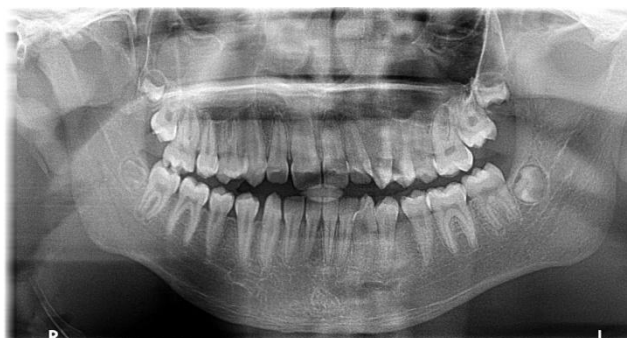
Radiographic aspects: class II of malocclusion, medial mandible line deviated 4 mm to the left
